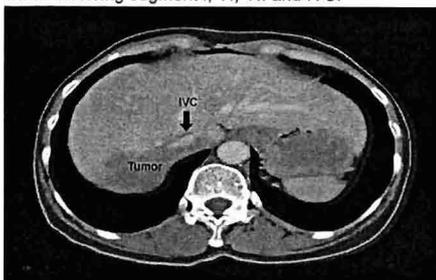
Transverse view of CT abdomen
